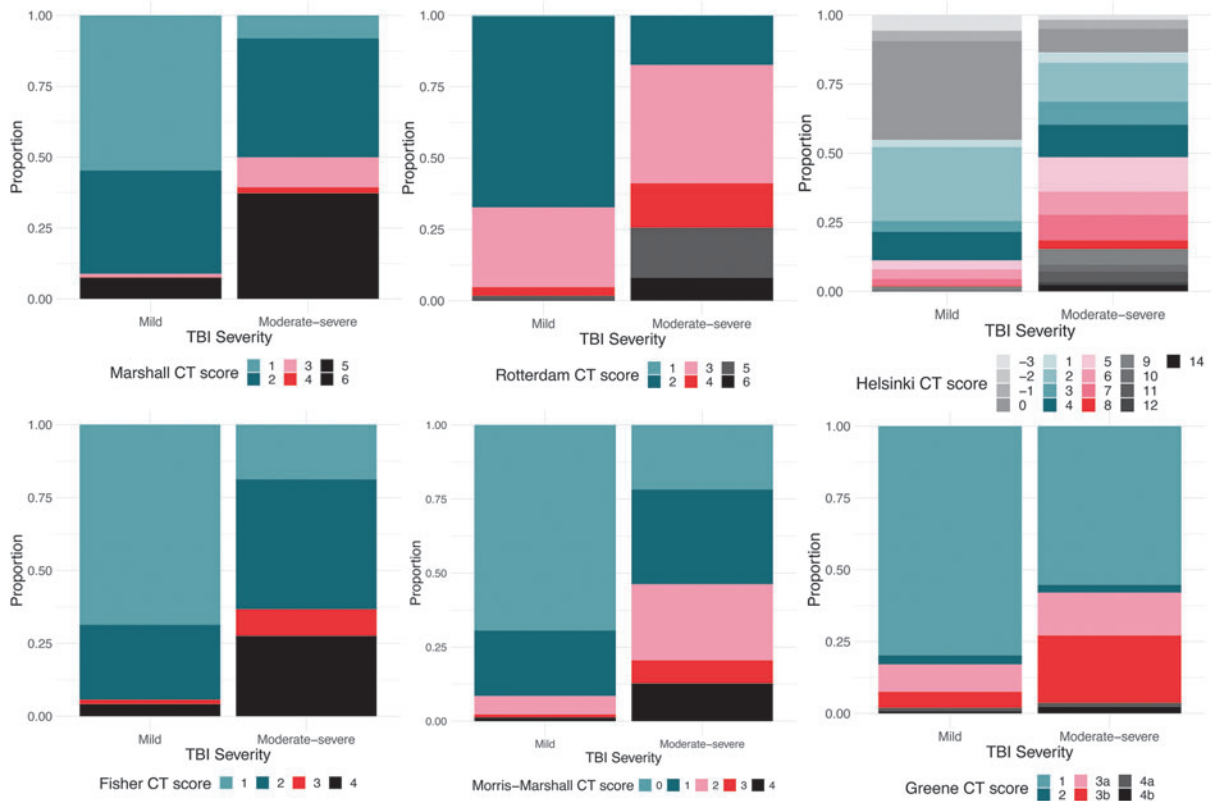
Traumatic brain injury (TBI) classification and grading system scores in the Collaborative European NeuroTrauma Effectiveness Research in TBI (CENTER-TBI) study, based on admission non-contrast computed tomography (CT) findings. The distribution of scores on the 6 CT classification systems and their association with mortality and unfavorable outcome at 6 months in CENTER-TBI is presented in Supplementary Table S19. In CENTER-TBI, Marshall CT scores 5 and 6 were combined.
